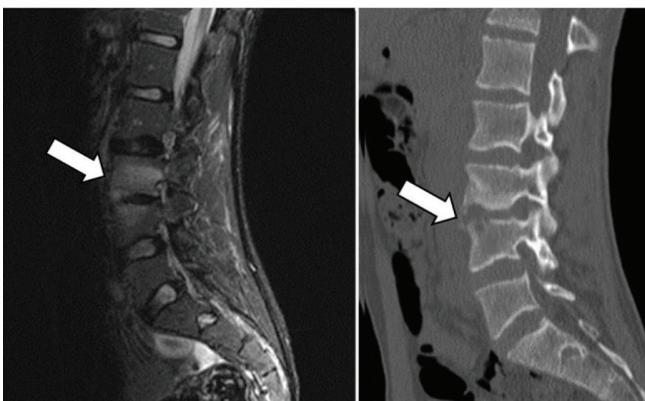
MRI and CT of 17-year-old male patient, inflammatory signal changes are observed in the L3-L4 disc and the vertebral end plateaus facing the disc in sagittal STIR images. There is moderate loss of height in the disc and lytic changes in the bone tissue in the vertebral end plateaus
